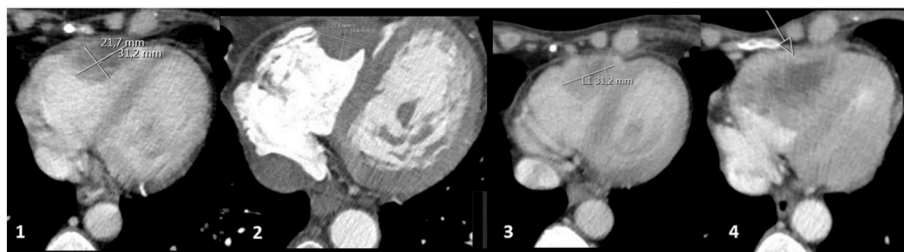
CT-scans showing cardiac metastasis at different time points during treatment: 1) before starting six cycles of chemotherapy, maximum diameter of 38 mm; 2) after two cycles of chemotherapy, maximum diameter of 30 mm; 3) after six cycles of chemotherapy, constant maximum diameter 30 mm; 4) two months after six cycles of chemotherapy, tumor mass filling two third of right ventricle.
